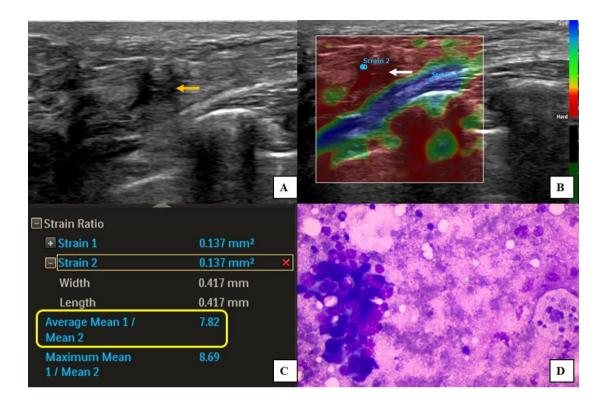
Ultrasonography in 32-year female patient with palpable left breast lump showed a spiculated solid lesion with posterior acoustic enhancement, suggestive of BIRADS 5 lesion (Fig A). On elastography, the lesion demonstrated uniform patterns of red colour (red colour was considered as hard) (score 2, thick white arrow) suggestive of malignant lesions (Fig B). Mean strain ratio is 7.82 suggestive of malignant solid lesion (Fig C). FNAC confirmed it as mastitis (Fig D).
